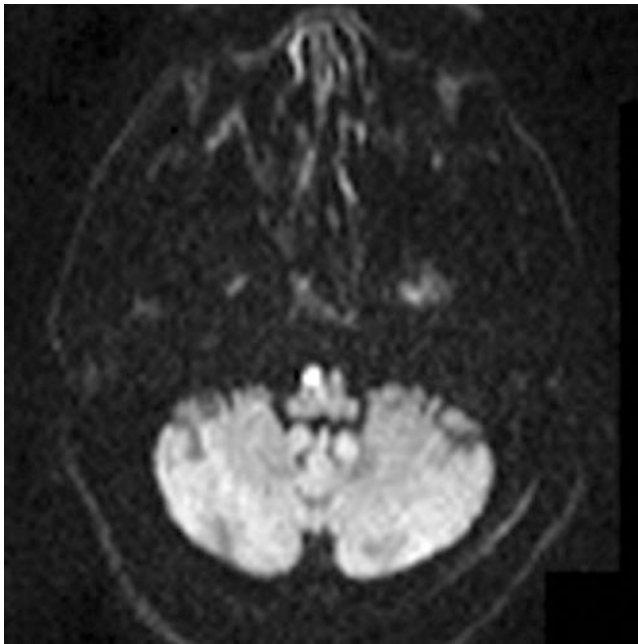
Medial medullary infarction. DWI shows acute infarction of right medullary pyramid in a patient with right vertebral dissection. The infarction is presumably due to occlusion of the anterior spinal artery, which arises from the distal V4 segment
